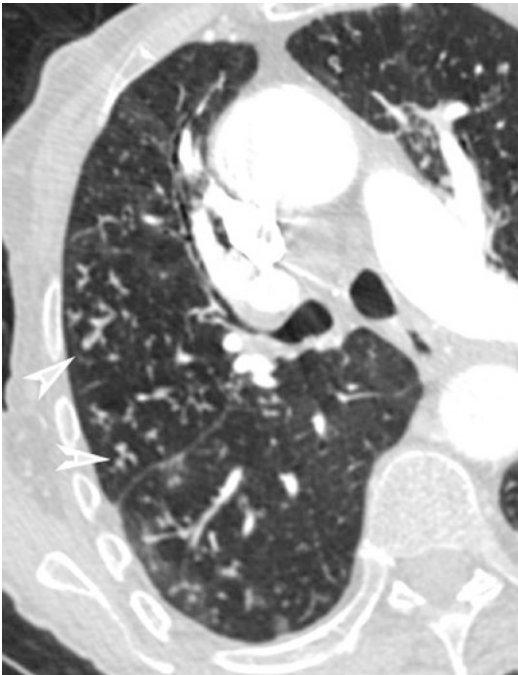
CT axial scan of the chest demonstrates the feeding vessel signs (arrowheads)
